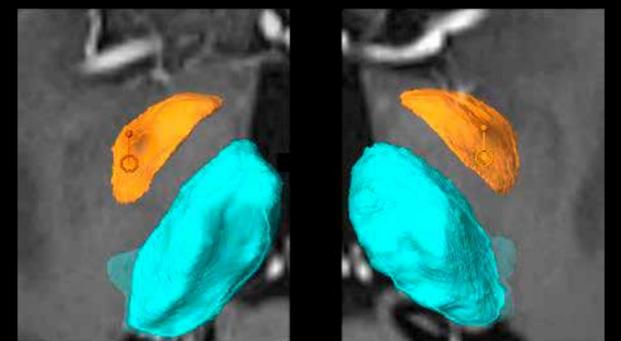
Preoperative 3T MRI protondensity image fused with postoperative CT images showing the positioning of the leads at the obtained target in bilateral GPi.
